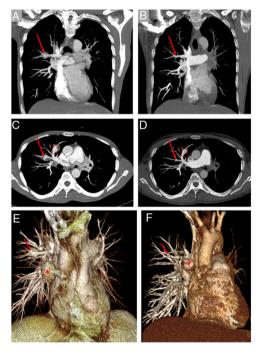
In presentation, coronal (A) and axial (C) MIP thorax CT angiography scans reveal aneurysms in the anterior (frame) and posterior (arrow) segmentary pulmonary arteries of the right upper lobe. In control examination eight months after corticosteroid and intravenous cyclophosphamide treatment, coronal (B) and axial (D) MIP thorax CT angiography scans show complete resolution (arrow) of the aneurysm in the posterior segmentary pulmonary artery of the right upper lobe. Aneurysm (frame) in the anterior segmentary pulmonary artery shows persistently in CT angiographic images. In presentation (E) and control examination (F), anterior view 3D volume rendering CT images reveal clearly persistent (asterisk) and shrinking (arrow) aneurysms.
